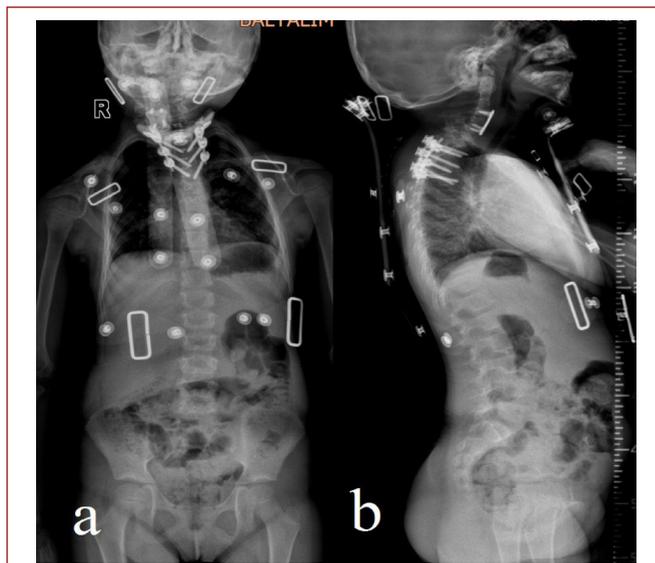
a) Postoperative anteroposterior X-ray, b) Preoperative lateral X-ray
